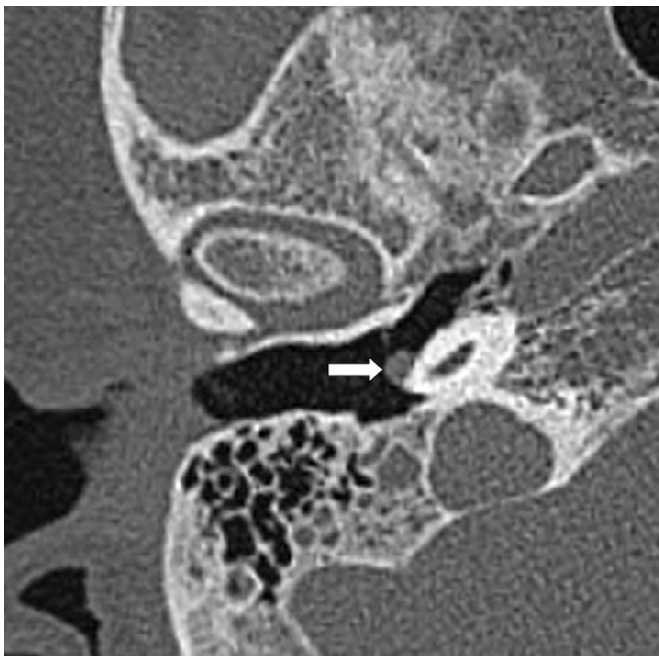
An axial computed tomography scan demonstrates that the glomus tympanicum tumor (arrow point) is located on the promontory.
